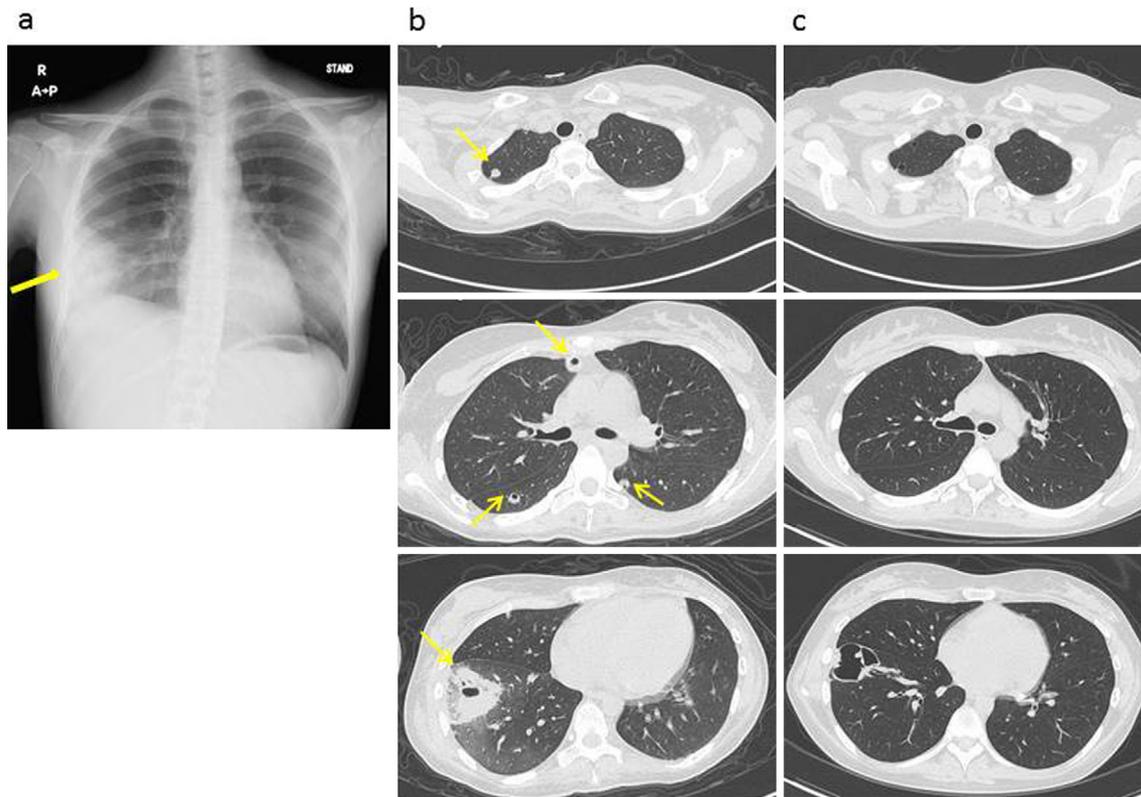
Diagnostic chest imaging. a: A chest X-ray obtained on the 25th day after admission revealed a nodular shadow in the right lower lung field. b: Chest CT performed on the 25th day after admission revealed multiple nodular shadows in both lung fields, compatible with a diagnosis of SPE. c: Chest CT performed after four weeks of treatment with LZD.
